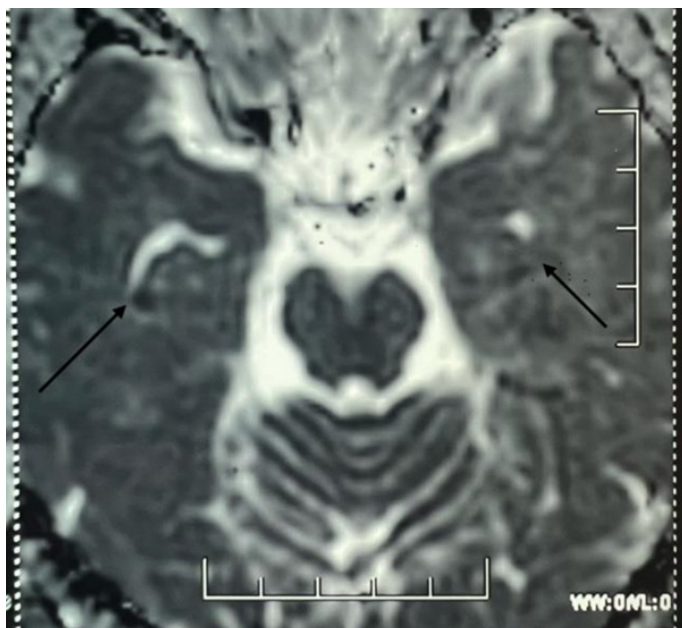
Axial MRI brain apparent diffusion coefficient image showing hypointensity in both hippocampi, CA1 region
